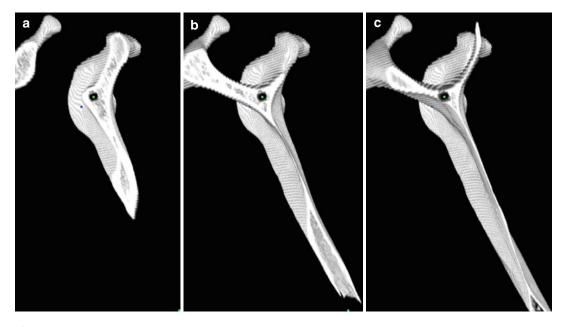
Cross-sectional CT scan images of a scapula with a central screw hole starting at the center of the glenoid articular surface and exiting at the junction of the scapula spine and medial border of the scapula (Reprinted from Codsi et al. [22] with permission from Elsevier). (a) Cross section of the scapula 2 cm medial to the glenoid surface, (b) Cross section in the middle of the scapula, (c) Cross section 2 cm from the medial border of the scapula
